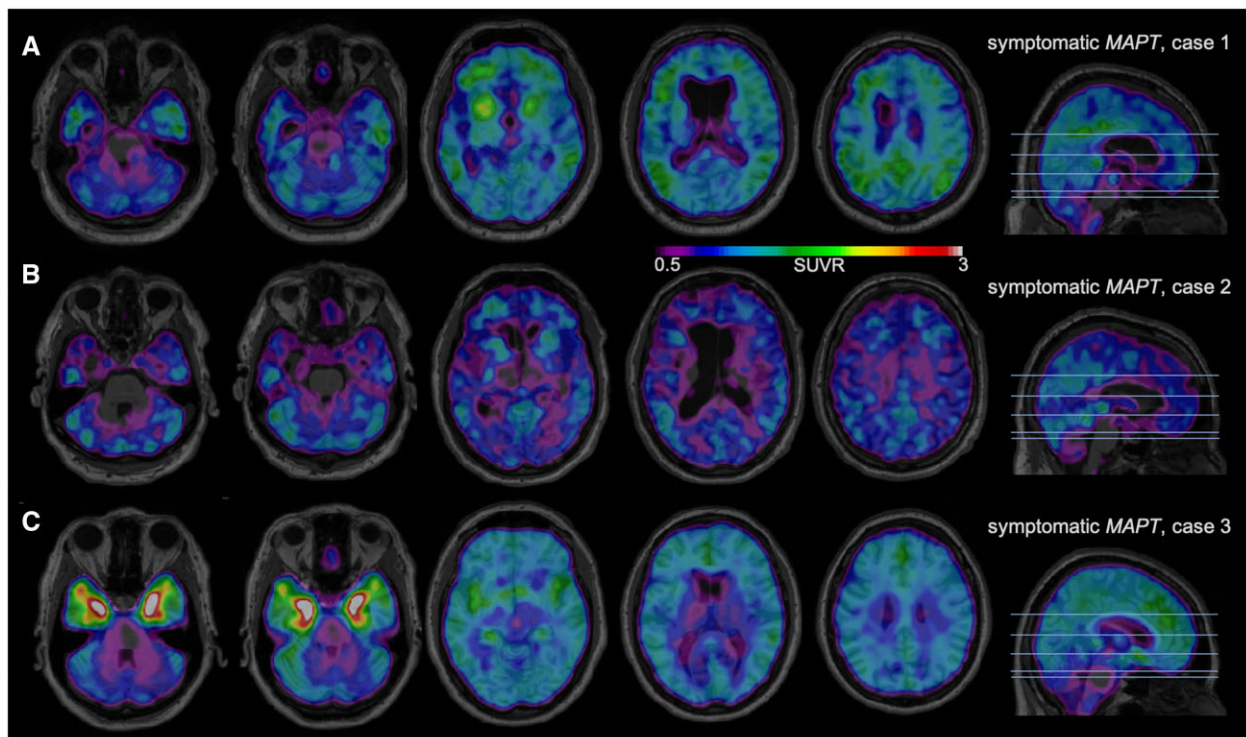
¹⁸F-MK-6240 tau-PET scans in symptomatic MAPT mutation subjects. A higher SUVR represents stronger binding. Binding to meninges, including the tentorium cerebelli, is considered to be off-target. Scans are masked to minimize off-target binding to meninges. (A) A 71-year-old male with bvFTD due to P301L MAPT mutation, FTLD-CDR 2, MMSE 6/30. (B) A 67-year-old male with bvFTD due to P301L MAPT mutation, FTLD-CDR 2, MMSE 8/30. (C) A 60-year-old female with bvFTD due to R406W MAPT mutation, FTLD-CDR 1, MMSE 29/30.
